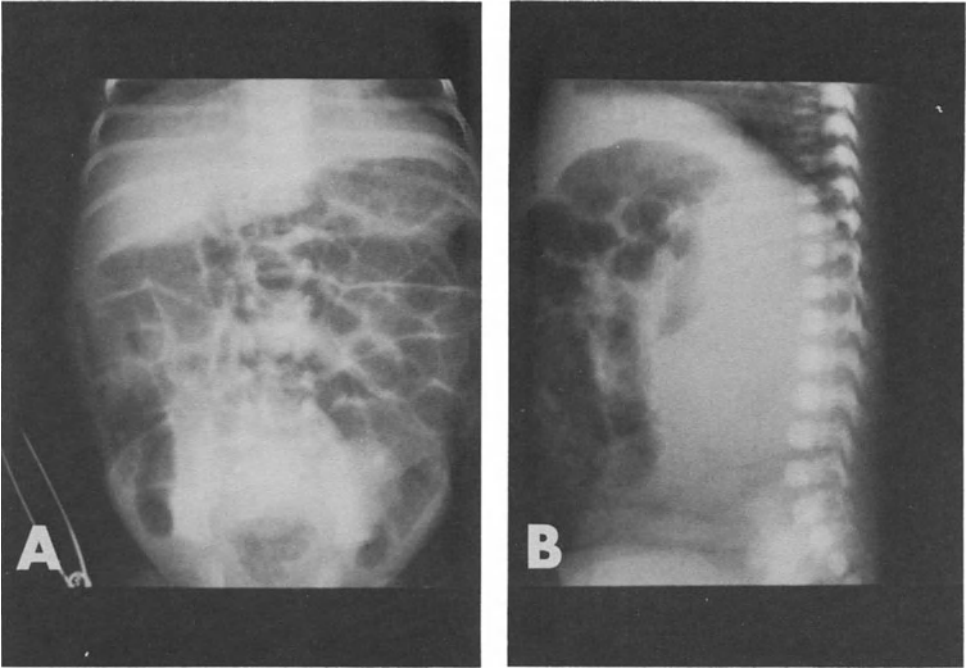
A. Anteroposterior and B. Lateral radiograph of a neonate with bilateral hydronephrosis secondary to posterior urethral valves. No obvious mass is identifiable on the frontal view, however, the lateral view demonstrates marked anterior displacement of all bowel loops indicating bilateral retroperitoneal masses. This patient's voiding cystourethrogram is shown in Figure 6.
